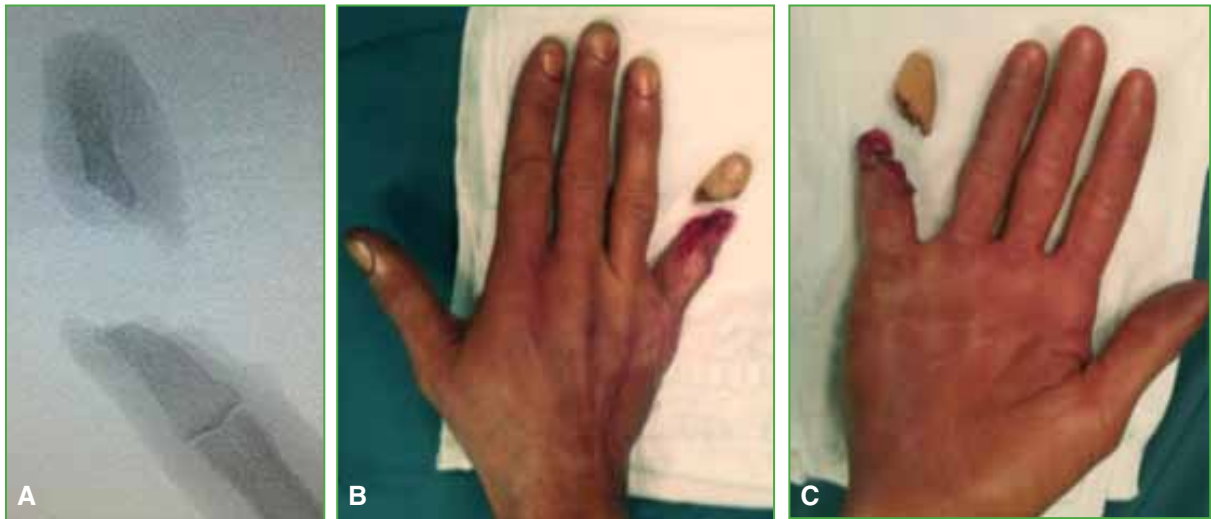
A. Intraoperative X-ray. Image shows the amputation bone level. B and C. Images of the part used for replantation.
